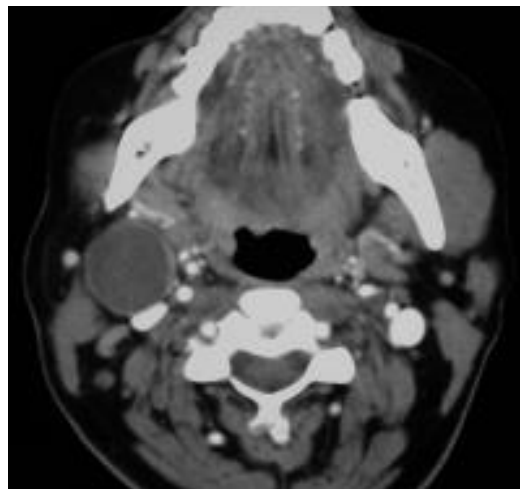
[25] - Cross-sectional CT scan of the neck of a patient
